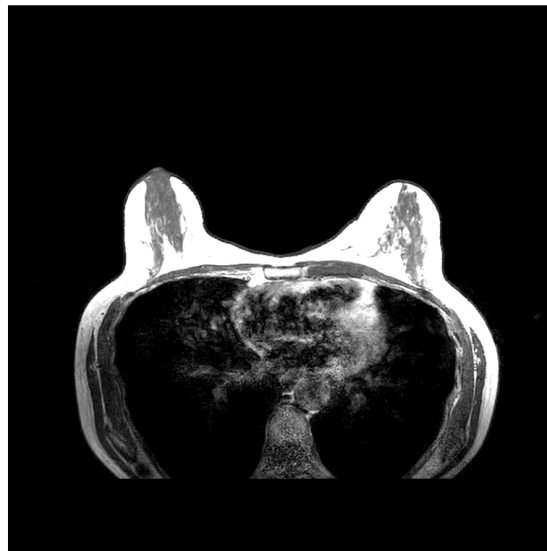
MR image example from an axial cut.
